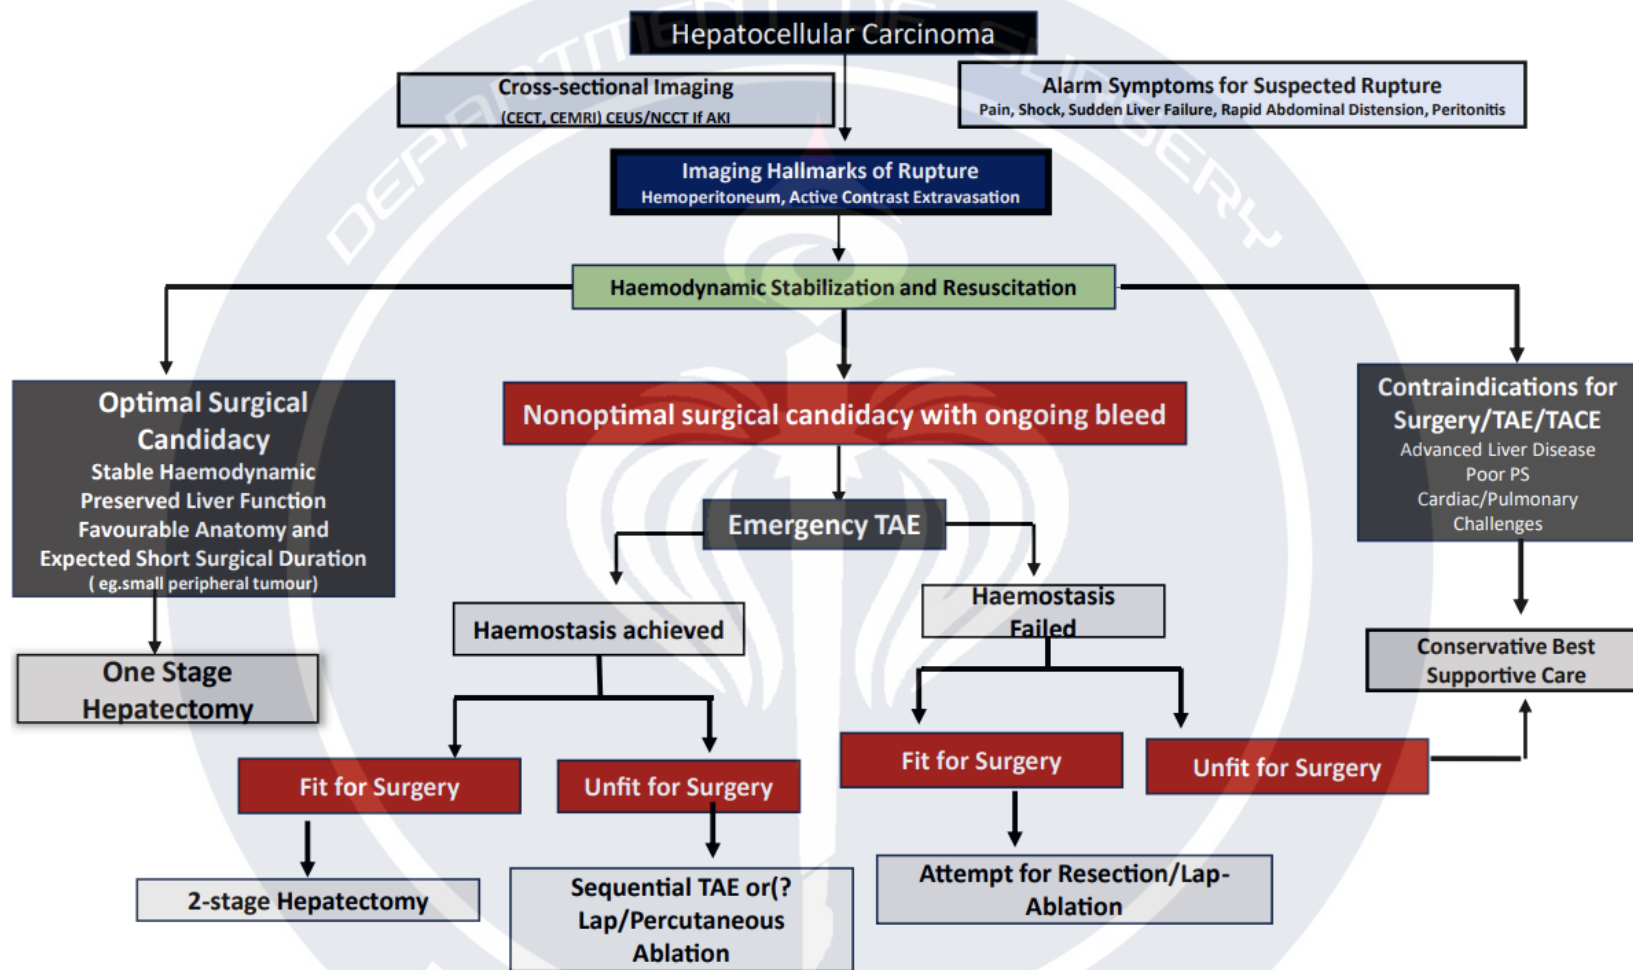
Algorithmic approach to ruptured HCC (AKI, acute kidney injury; CECT, contrast enhanced CT; CEMRI, contrast enhanced MRI; CEUS, contrast enhanced ultra sound; HCC, hepatocellular carcinoma; NCCT, non contrast CT; TACE, transarterial chemoembolisation; TAE, transarterial embolisation).
